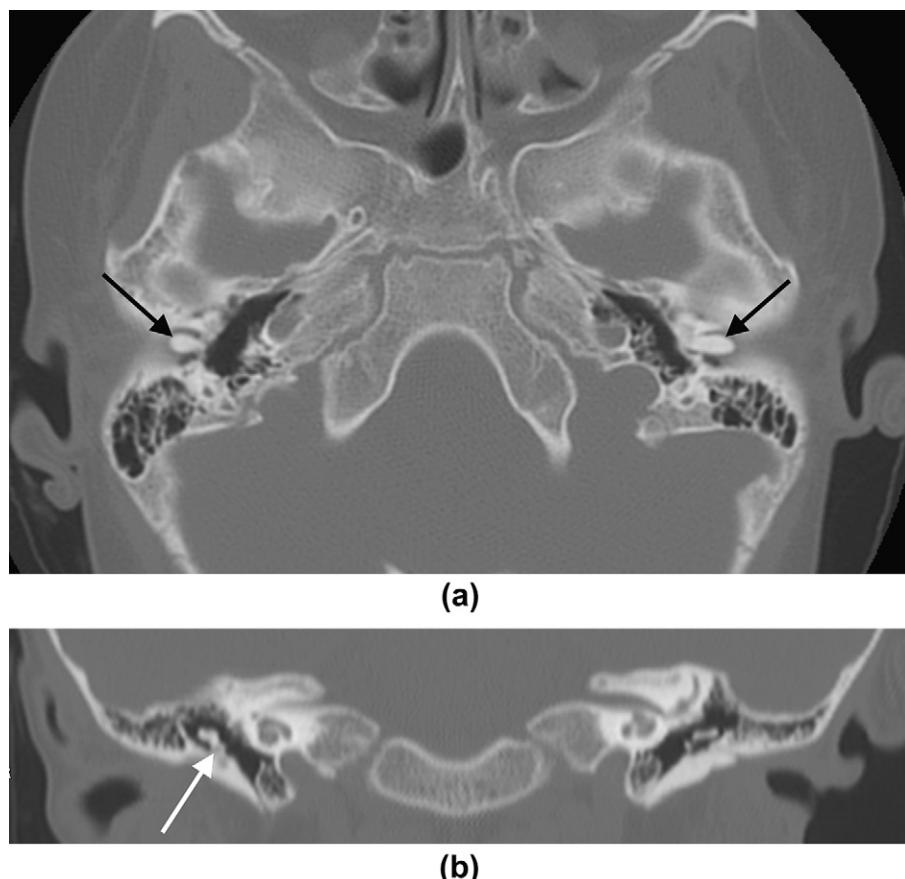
A 4-year-old patient with conductive hearing loss and microtia. Axial HRCT (a) demonstrates bilateral bony atretic plates (black arrows) lying medially in the EACs. A coronal reformat (b) shows fusion of the handle of the right malleus to the atretic plate (white arrow). The pinnae are seen to be hypoplastic. The patient was ultimately fitted with a BAHA.
